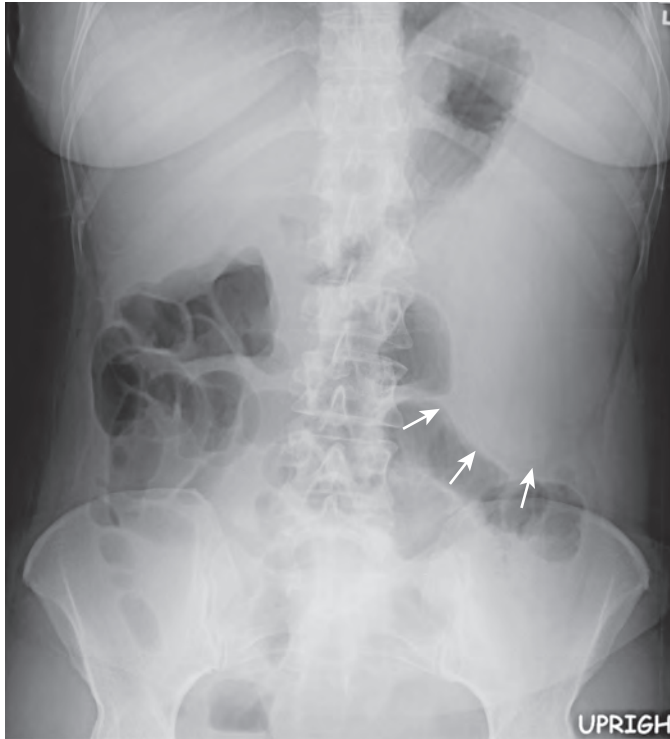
Splenomegaly. Supine abdominal radiograph shows marked splenic enlargement (arrows) with displacement of bowel inferiorly.
